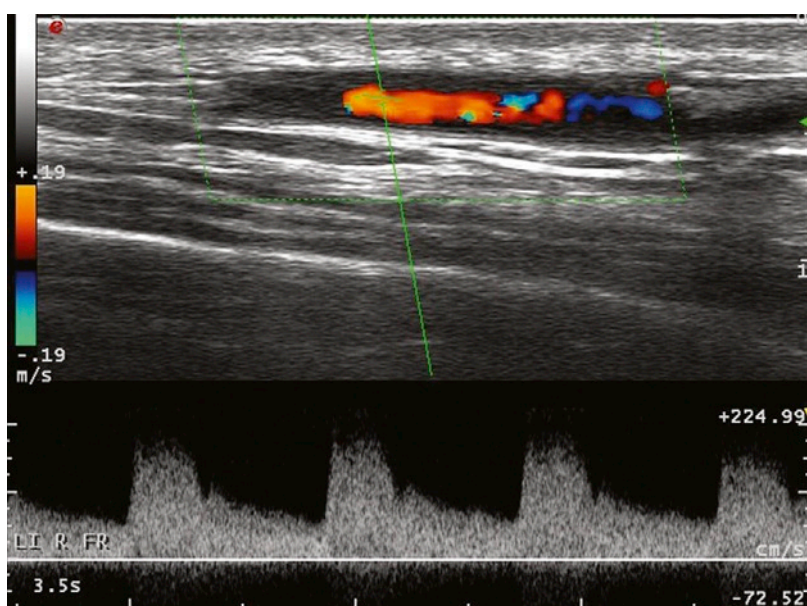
Duplex ultrasound of the frontal branch in a patient with acute temporal arteritis shows hypoechoic wall swelling. The power-wave Doppler curves show increased systolic and diastolic flow velocities. The maximum systolic flow velocity is 180 cm/s.
